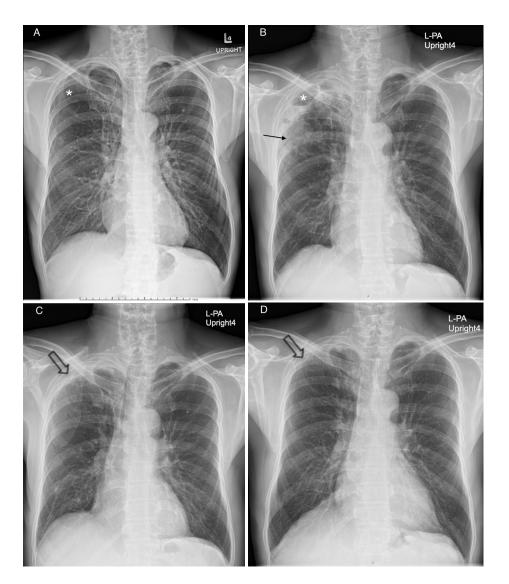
Chest radiograph PA upright in 2013 (A) shows a thin-wall air-filled cavity compatible with a bulla in the RUL (asterisk). In February 2018, chest radiograph (B) shows the previously seen bulla (asterisk) with a new surrounding patchy opacity (black arrow). The follow-up chest images after treatment in March 2018 (C) and in December 2020 (D) show smaller size of the cavitary lesion with gradually improved right apical pleural thickening (open arrows), compatible with partial regression of the lung bullae.
